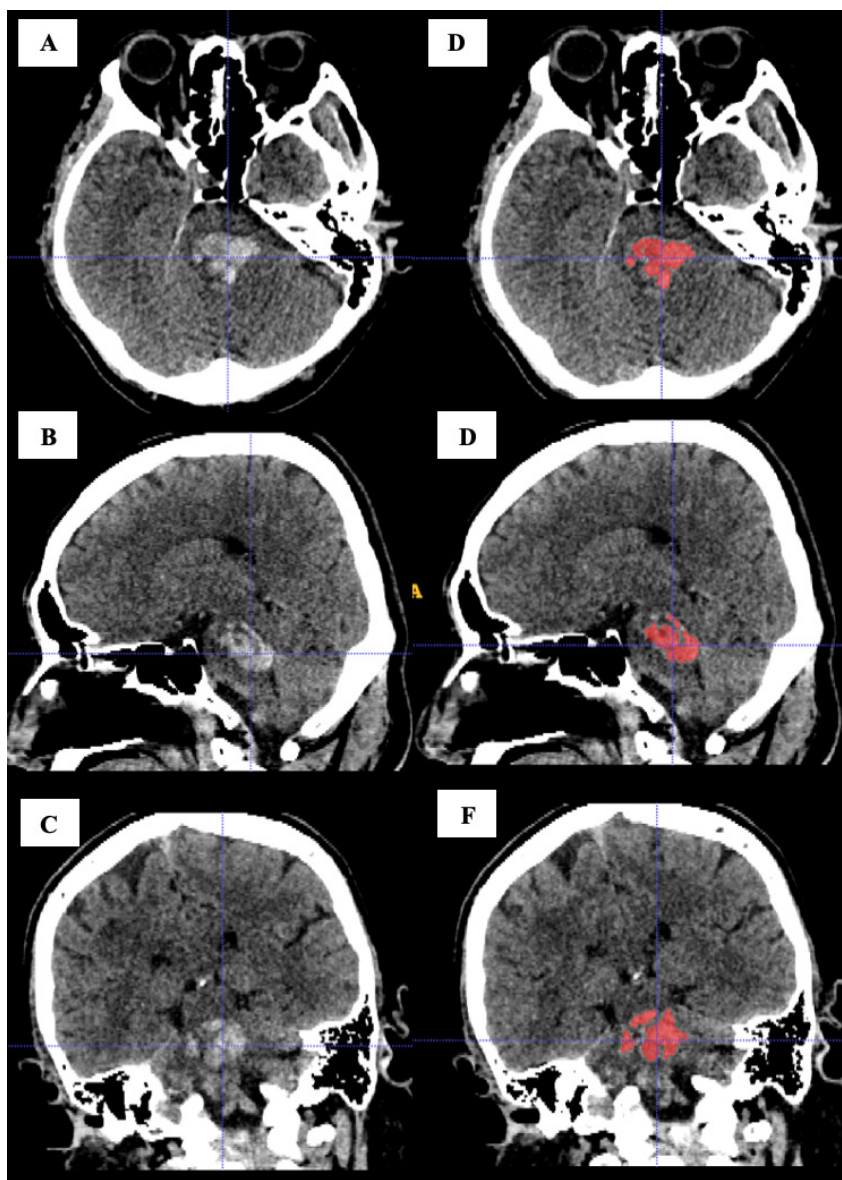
Non-contrast enhanced CT brain. Axial, sagittal and coronal views (A-C) showing the acute brainstem haematoma and segmentation of the haematoma in axial, sagittal and coronal views (D-F).
